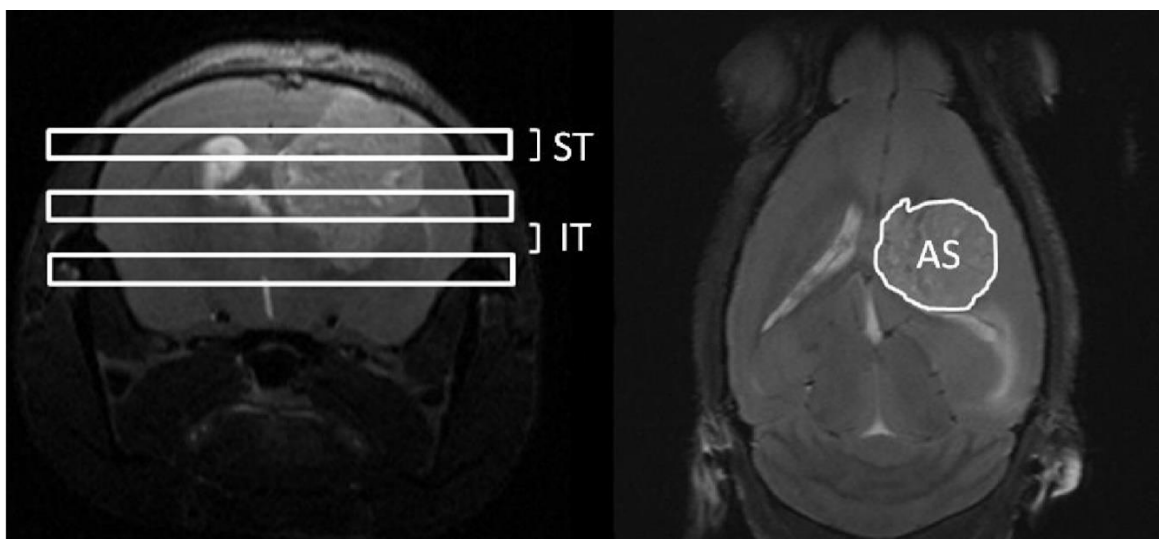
MRI measurement for tumor volume assessment. High resolution axial  $T_{2w}$  images (right) were acquired for this purpose. The surface area (AS) of the tumour (white line contour at right) was measured in each slice of the axial  $T_{2w}$  images. The slice thickness (ST) and the inter-slice thickness (IT) (represented by horizontal slices over a coronal image on the left) were considered for final volume calculation. Figure adapted from reference 138.
